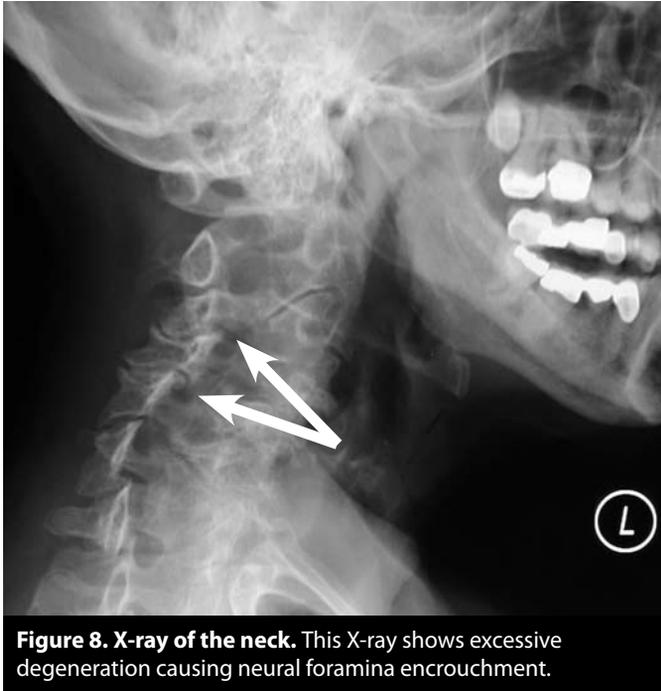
X-ray of the neck. This X-ray shows excessive degeneration causing neural foramina encroachment.
